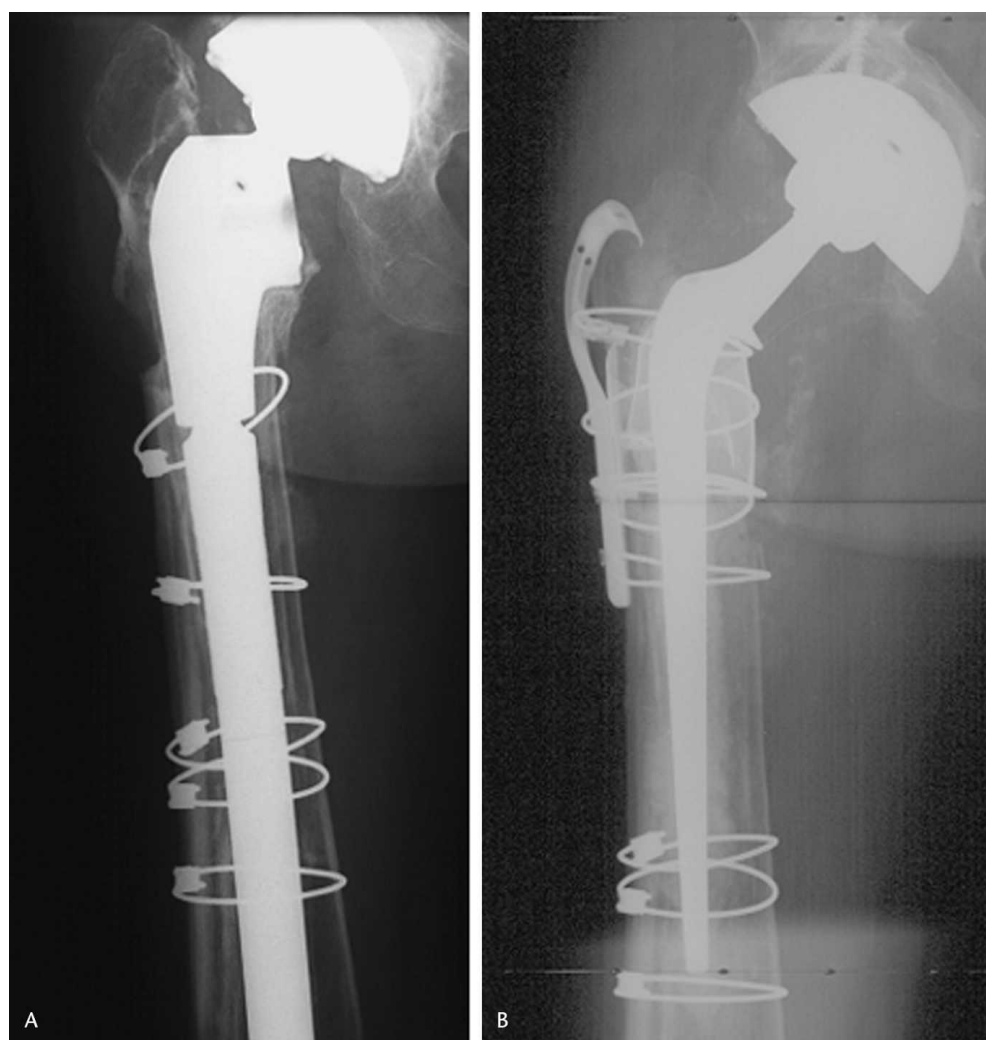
(A) A radiograph shows trochanteric nonunion associated with loose cementless components. (B) The large trochanteric fragment was advanced and reattached successfully using a cable plate, restoring abductor function.
